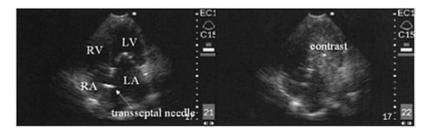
Portable echocardiography during percutaneous transvenous balloon mitral valvuloplasty. Left panel: a transseptal needle is seen across the atrial septum. Right panel: a small amont of agitated contrast media is injected from a transseptal catheter to confirm the position of its tip. Contrast echo is seen in the left atrium and flows to the left ventricle, showing the correct positioning of the catheter.
